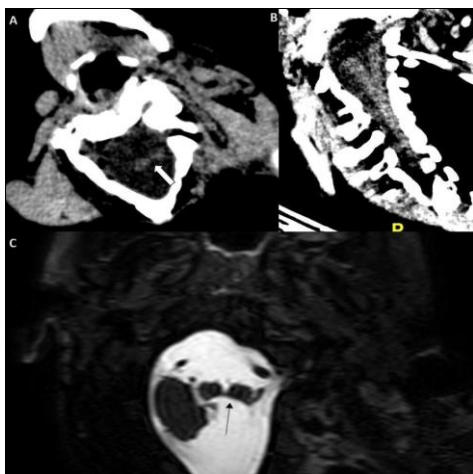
Image A is the axial section of the CT cervical spine and Image B is the coronal MPR reconstruction of the CT cervical spine showing splitting of the high cervical cord (marked by a white block arrow) suggestive of cervical diastematomyelia. Image C is the T2W axial section showing the splitting of the cervical cord (as marked by a black line arrow).
